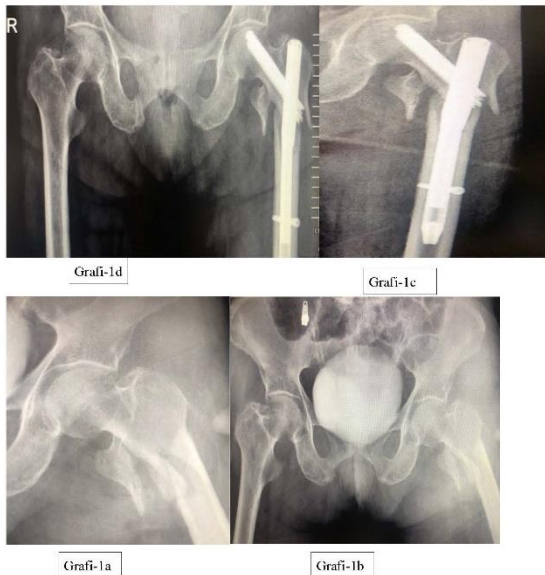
a: AP X-ray of the left hip, pertrochanteric hip fracture. b: Pelvis AP X-ray, pertrochanteric hip fracture. c: Hip AP X-ray at 1 month after 1st PFN surgery. d: Pelvic AP X-ray at 1 month after 1st PFN surgery.
